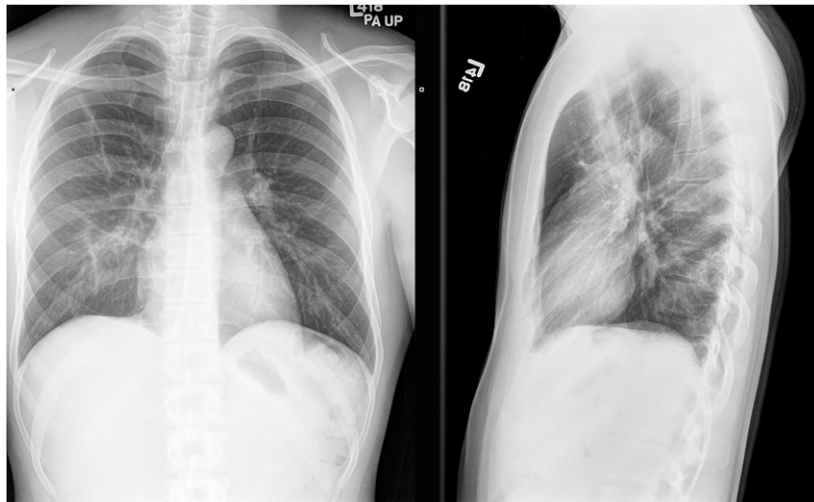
Posteroanterior (PA) and lateral chest X-rays, revealing resolution of the previously seen right-sided pleural effusion after treatment with prednisone.
